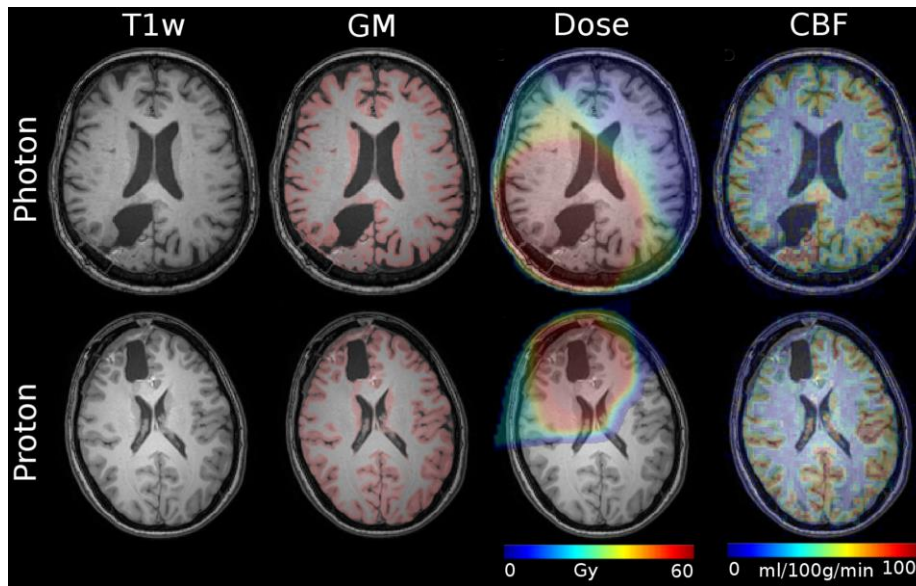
Example of using advanced MRI to determine the effect of radiochemotherapy on healthy tissue. *From left to right:* T1-weighted structural images, T1-weighted overlaid with a segmentation of the grey matter (GM) in red, calculated total radiation-dose, and cerebral blood flow (CBF) maps acquired using arterial spin labeling MRI. Images from patients treated with photon therapy (top row) and proton beam therapy (bottom row).
